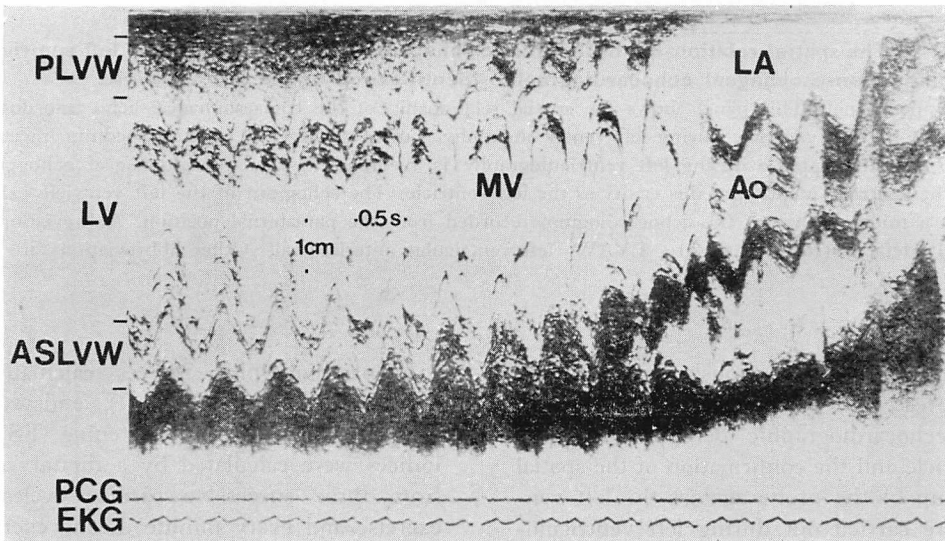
Transesophageal echocardiographic M-mode scan from the left ventricle to the aorta.
